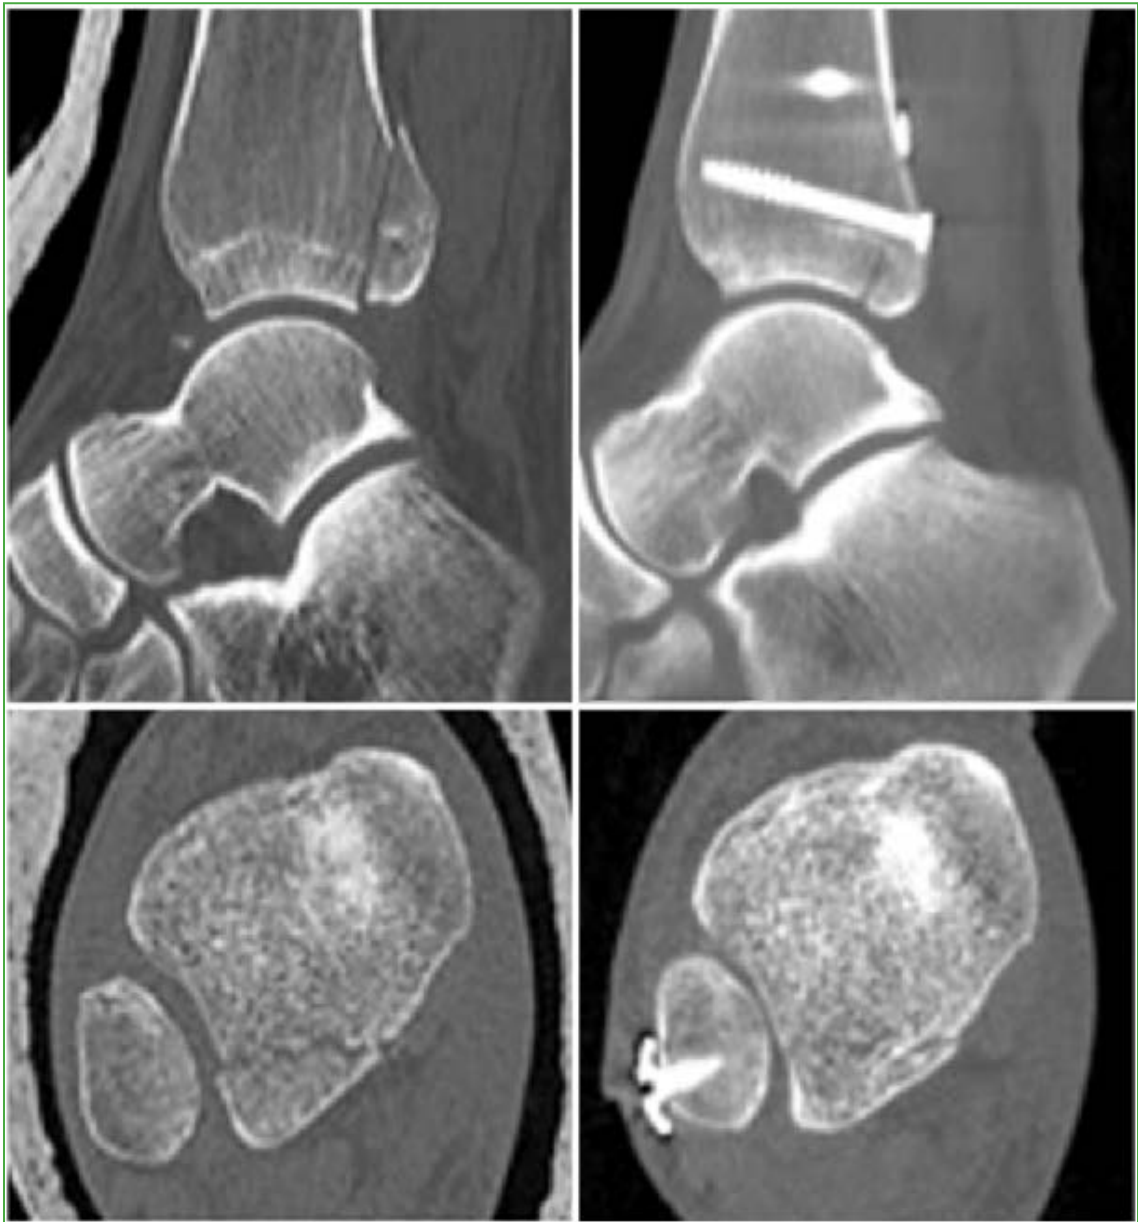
Quality of posterior malleolar reduction assessed by computed tomography in the immediate postoperative period: anatomical reduction. No displacement is observed.
